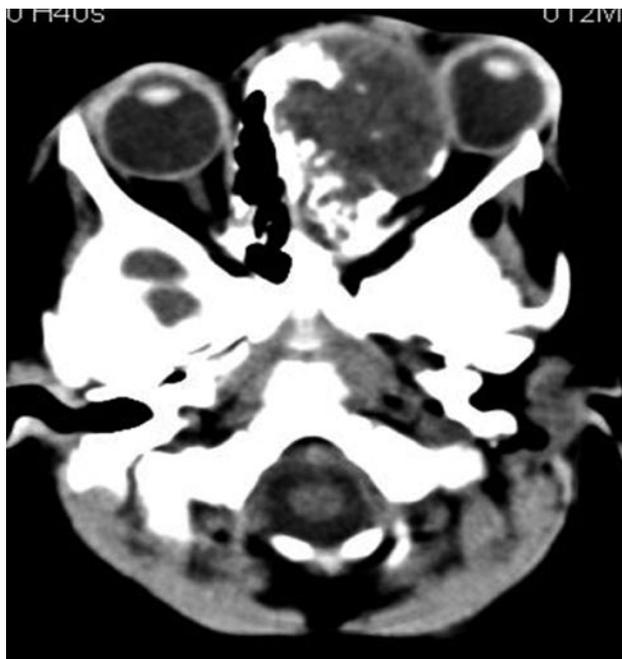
Plain axial CT scan shows a large expansile low-attenuation mass originating in left nasal cavity with extension into left orbit. There are subtle chondroid matrix mineralizations within the mass.
